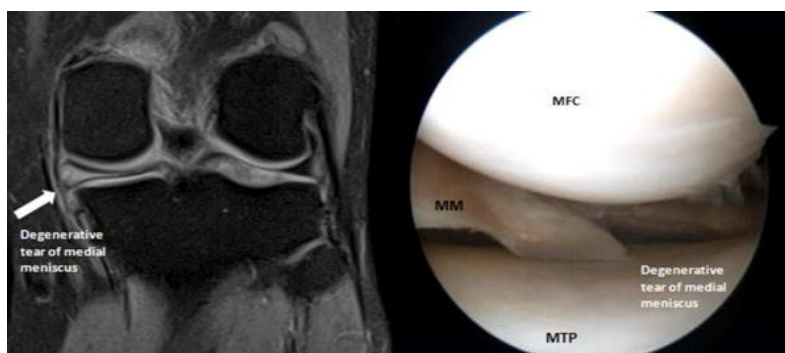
Degenerative medial meniscus (MM) tear revealed on the MRI scan: (empty meniscus body indicated by arrow) and during arthroscopy in the left knee joint with the arthroscope introduced through the anterolateral viewing portal. (MFC, medial femoral condyle; MTP, medial tibial plateau)⁽²⁵⁾.
